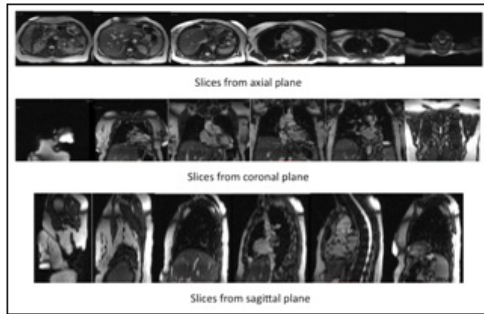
Views of MRI slices.
